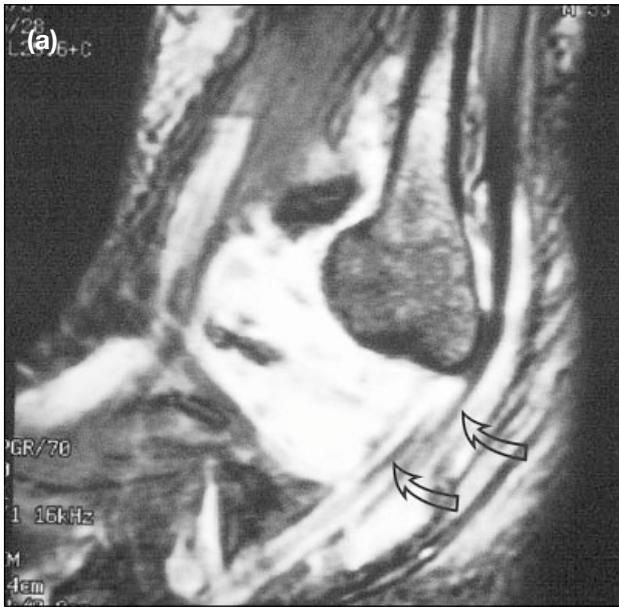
Patient with increasing restriction of ankle movement due to rheumatoid arthritis. Postcontrast-enhanced images: (a) sagittal spoiled GRASS (TR 60 ms/TE 12 ms, flip angle 70°) and (b) coronal T1-weighted (TR 420 ms/TE 19 ms). In (a), a large quantity of brightly-enhancing synovium can be appreciated around the lateral malleolus and surrounding the peroneal tendons (curved arrows). In (b), the tendon sheaths are filled with enhancing synovium (curved arrows). These findings promote the development of tarsal tunnel syndrome, as well as rupture of tendons.
